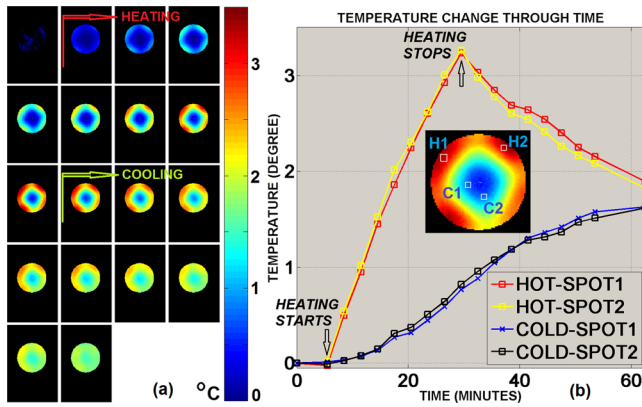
(a) Under B1-shim I, measured temperature change using MRI Thermometry; the first phase image acquired before heating was used as the reference. (b) Time course of measured temperature change at four local “hot” and “cold” spots.
